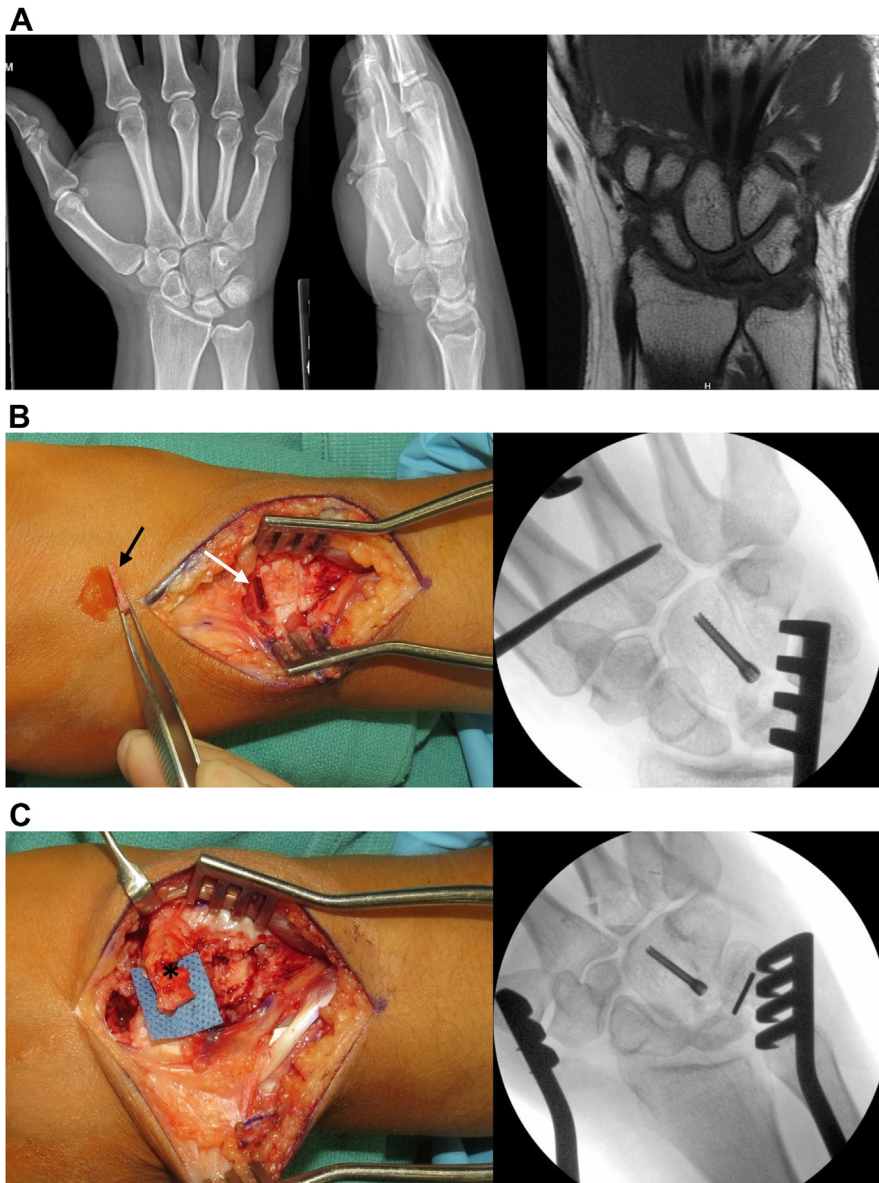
Transfer of vascularized third metacarpal base flap into the lunate and capitate-shortening osteotomy. (A) Radiographs and MRI of a patient with Kienbock disease and an ulnar neutral wrist. (B) Intraoperative photograph of capitate osteotomy (*white arrow*) with removal of a wedge of bone (*black arrow*) and fluoroscopic image of fixation with a compression screw. (C) Intraoperative photograph of metacarpal flap harvest on its pedicle (*) and fluoroscopic image of fixation to the lunate with a Kirschner wire.
